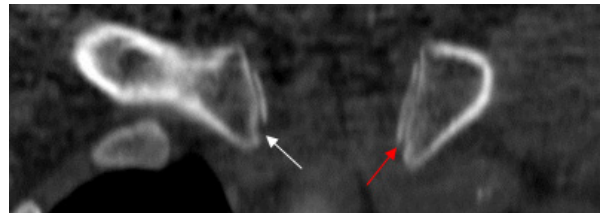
CT image of medial clavicles of a 17 year old female shows stage 2a (white arrow) ossification of the right and stage 2c of the left epiphyseal cartilage (red arrow)
